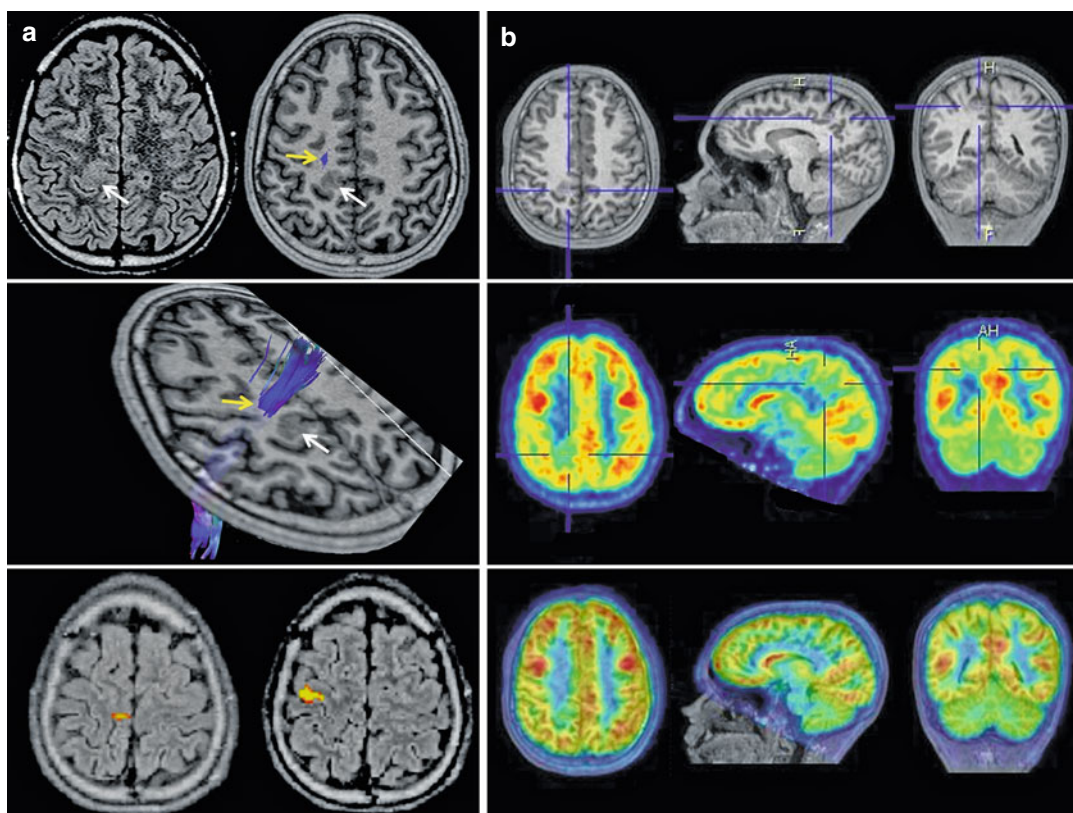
Multimodal diagnostic workup in a 17-year-old boy with refractory epilepsy candidate to surgery. (a) Morphological FLAIR and T1-weighted MRI images show a focal cortical dysplasia in the right mesial perirolandic cortex (white arrows, upper and middle rows). Diffusion-tensor imaging (tractography) demonstrates the location of the motor component of the right corticospinal
